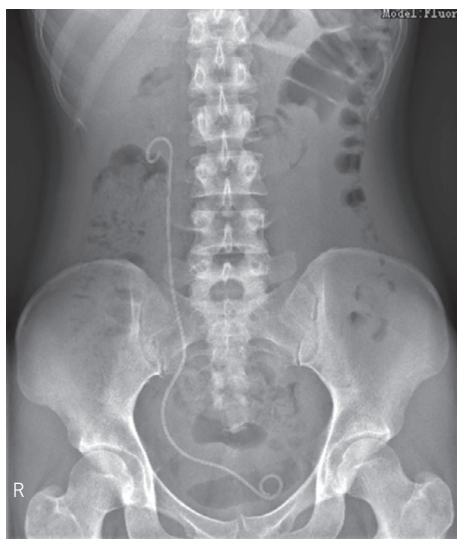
Kidney, ureter, and bladder radiography on postoperative day 1.
